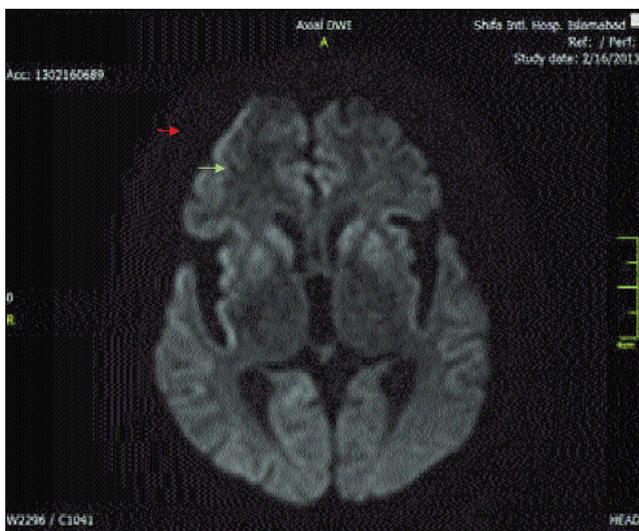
Subtle increased signal in bilateral caudate and lentiform nucleus (green arrow) and subcortical ribboning (red arrow) on DWI.
